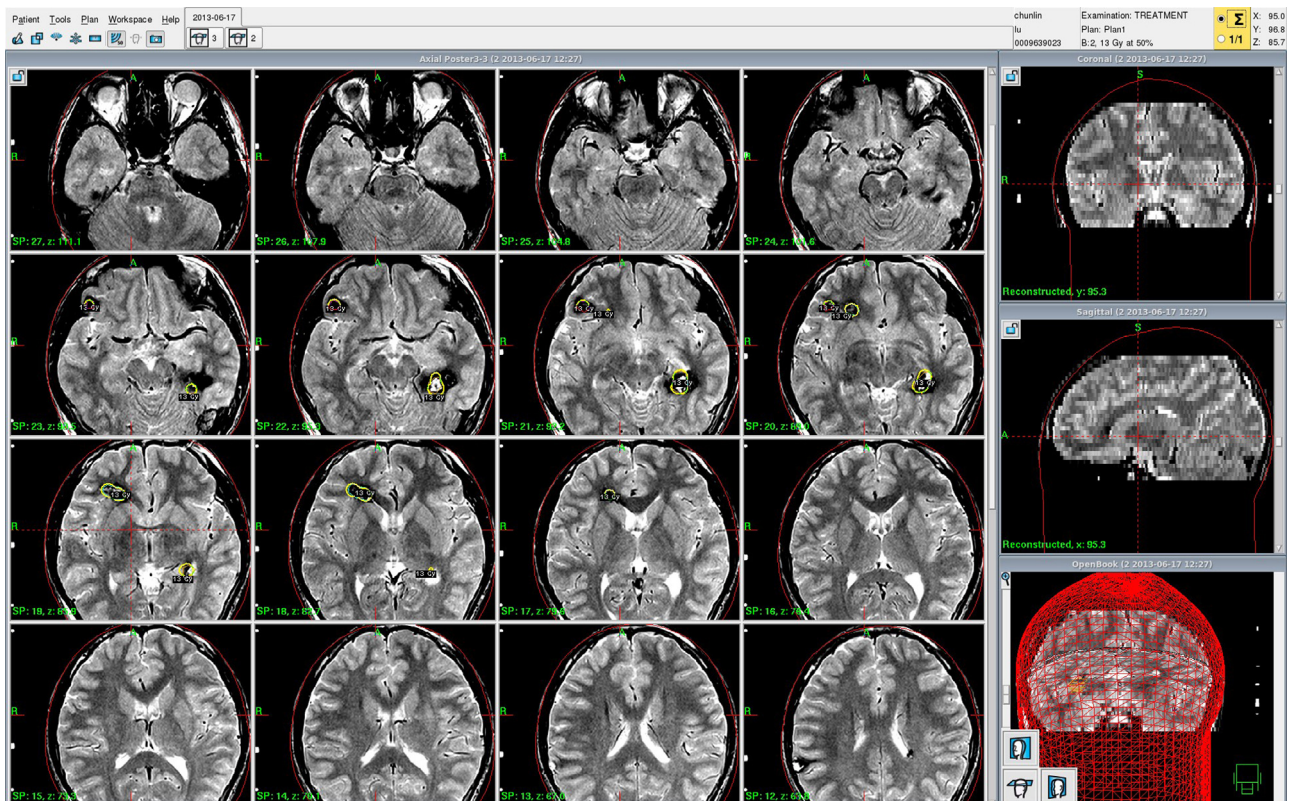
a and b Case 1. GKS planning for FCCM. This 14-year-old male harboring multiple lesions within his brain underwent GKS twice. Isodose lines for planning are clearly seen on MR images.
